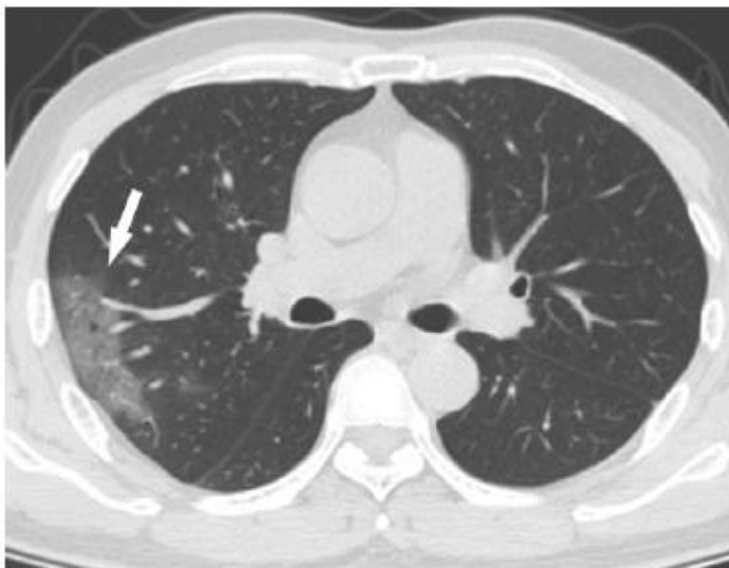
CT findings of patchy ground glass pattern in a confirmed case of COVID-19. (Zu *et al.*, 2020).
